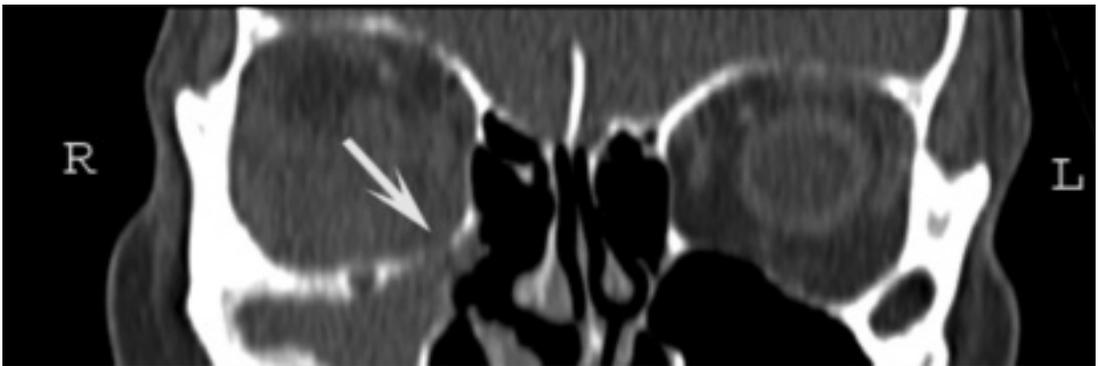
coronal CT scan showing orbital involvement (arrow).
